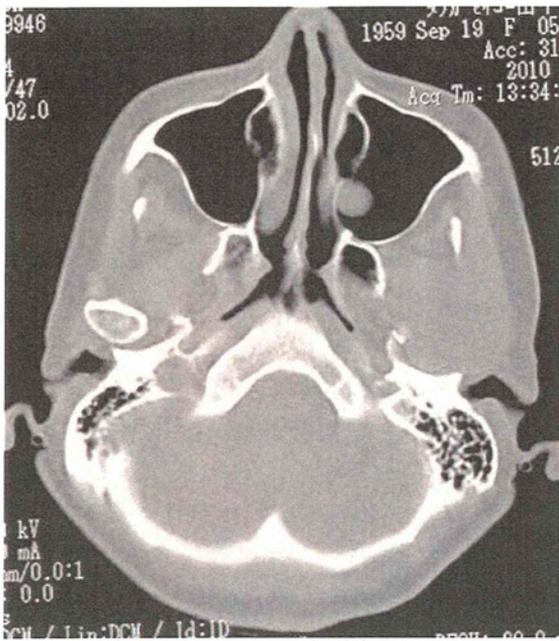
CT (bone window setting) demonstrated an expansive soft tissue mass and resorption of the left mandibular condyle.
